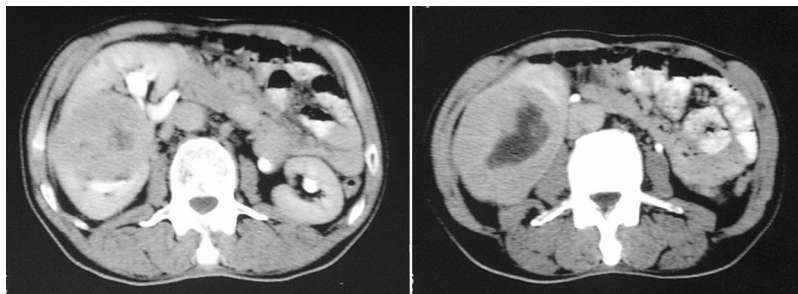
Well-defined tumoral mass with an enhancing central scar on CT
